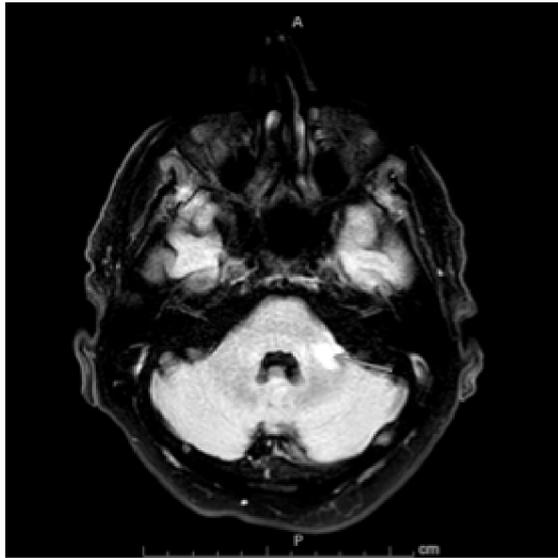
T2 FLAIR Axial View. 4mm hyperintense peripheral nodule located in left brachium pontis (arrow)
